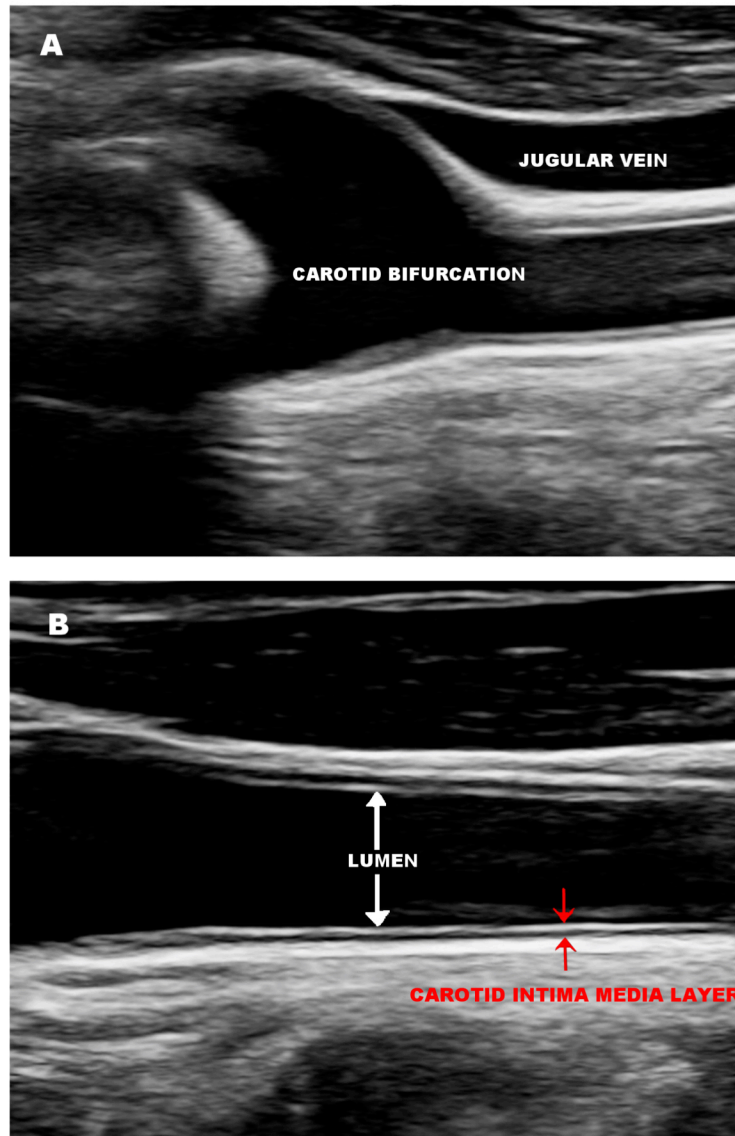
B-mode ultrasonography of the carotid artery.
